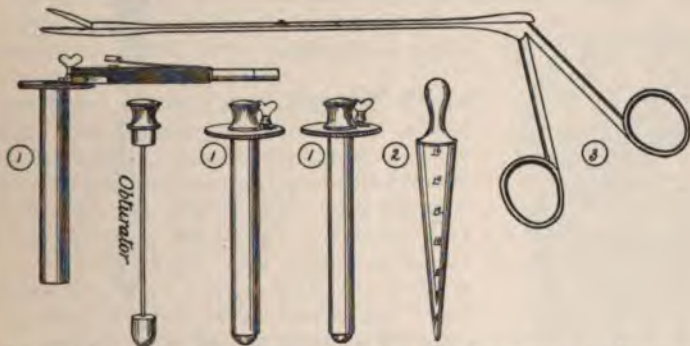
INSTRUMENTS FOR URETHROSCOPY OR INDIRECT INSPECTION OF THE URETHRA.
